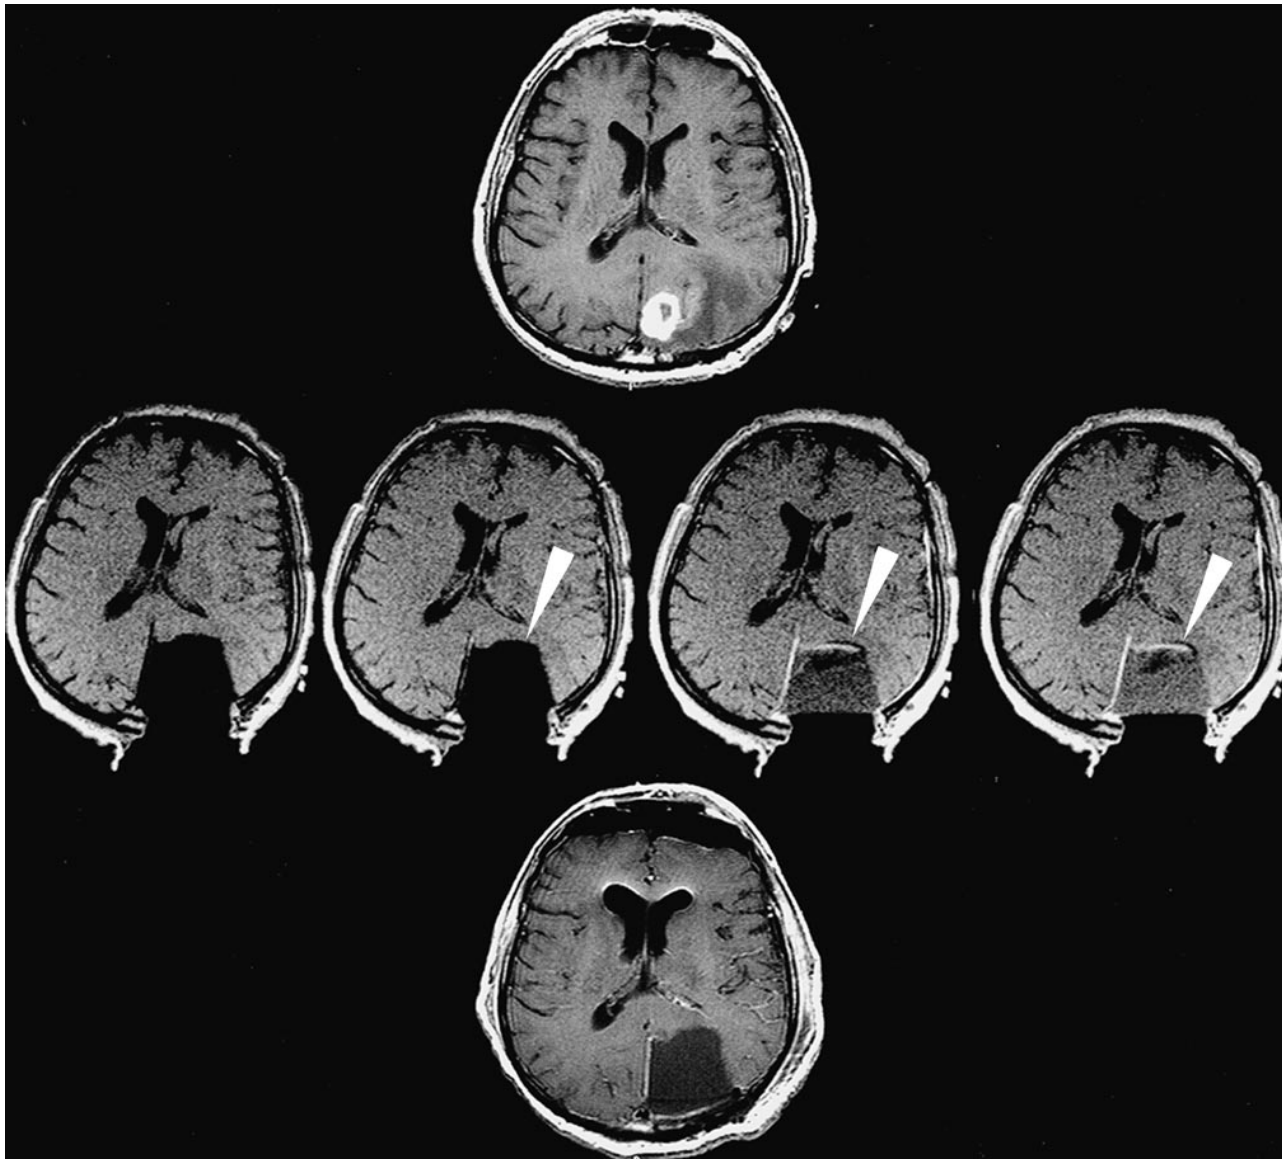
Surgically induced, delayed (time-dependent) enhancement at the resection margins. Preoperative MR image (*top*) (674/20/2) shows a left occipital, contrast-enhancing tumor. Intraoperative T1-weighted images (*middle* [from *left to right*], unenhanced and 5, 10, and 20 minutes postcontrast) (532/15/3) show linear enhancement at the resection margin, which is more pronounced the more time has elapsed since the administration of the contrast agent (*arrows*). Also note the diffusion of the contrast agent into the fluid-filled resection cavity, leading to increased signal intensity of the fluid on the delayed images. The probable cause of this type of surgically induced contrast enhancement is leakage of contrast agent out of surgically opened blood vessels. The enhancement is not present on the preoperative (*top*) or postoperative (*bottom*) MR images (674/20/2).
